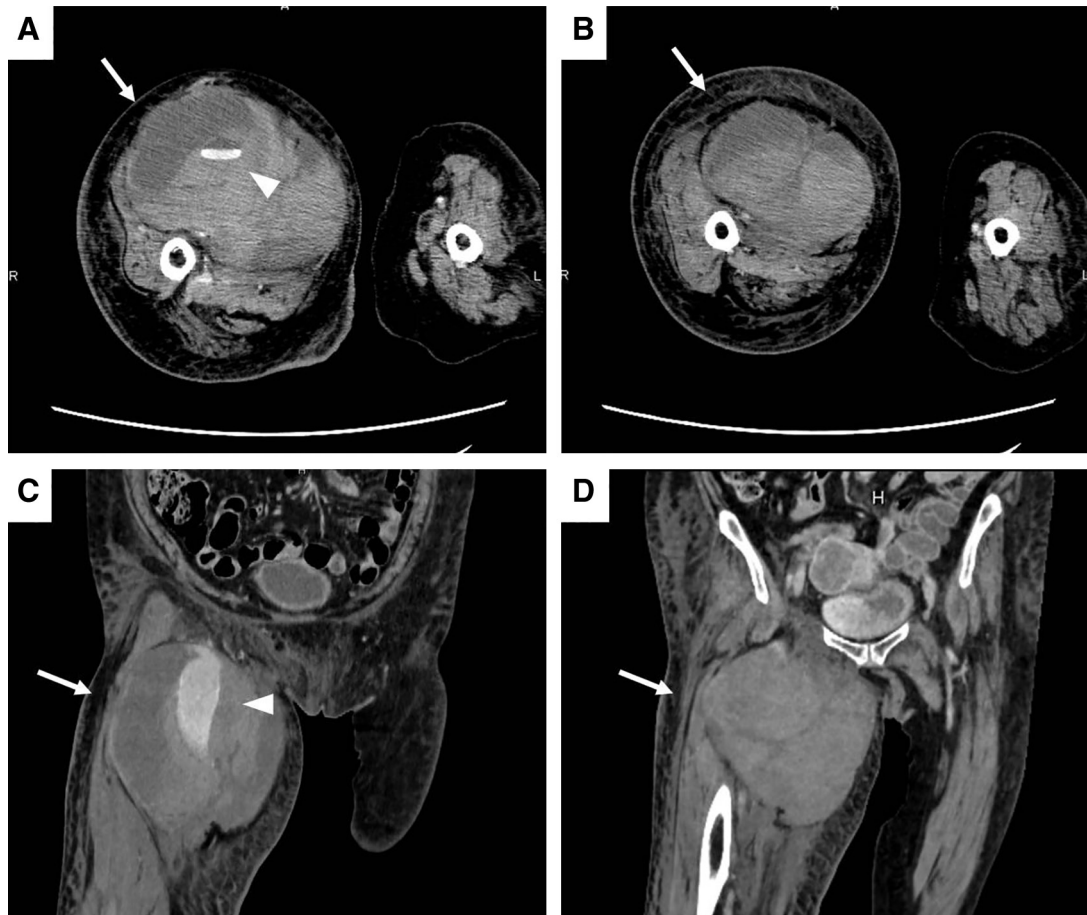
Horizontal view (A, B) and coronal view (C, D) on contrast-enhanced CT of the lower limb when the pseudoaneurysm ruptured at 35 days after onset: A giant pseudoaneurysm accompanied by right thigh hematoma was observed (arrow). Leakage of contrast medium was noted in a part of the pseudoaneurysm (arrowhead).
